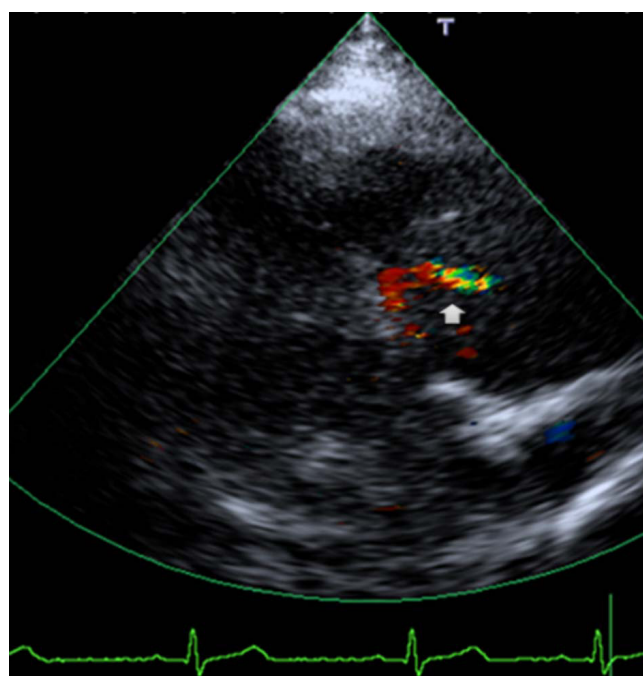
Echocardiographic images showing a mosaic flow in the right ventricle (arrow).
